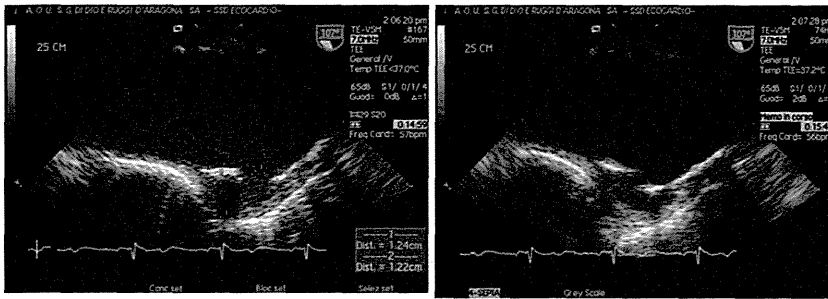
▲ Penetrating atherosclerotic ulcer. Transesophageal echocardiography: ulcer-like formation in the inferior wall of the aortic arch with disruption of the internal elastic lamina before (*left panel*) and after (*right panel*) contrast agent administration. (Courtesy of Rodolfo Citro, MD, Heart Department, University Hospital “San Giovanni di Dio e Ruggi d’Aragona”, Salerno, Italy)
